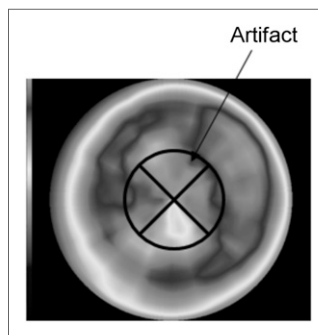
Apical artifact appearing with upright D-SPECT imaging.
